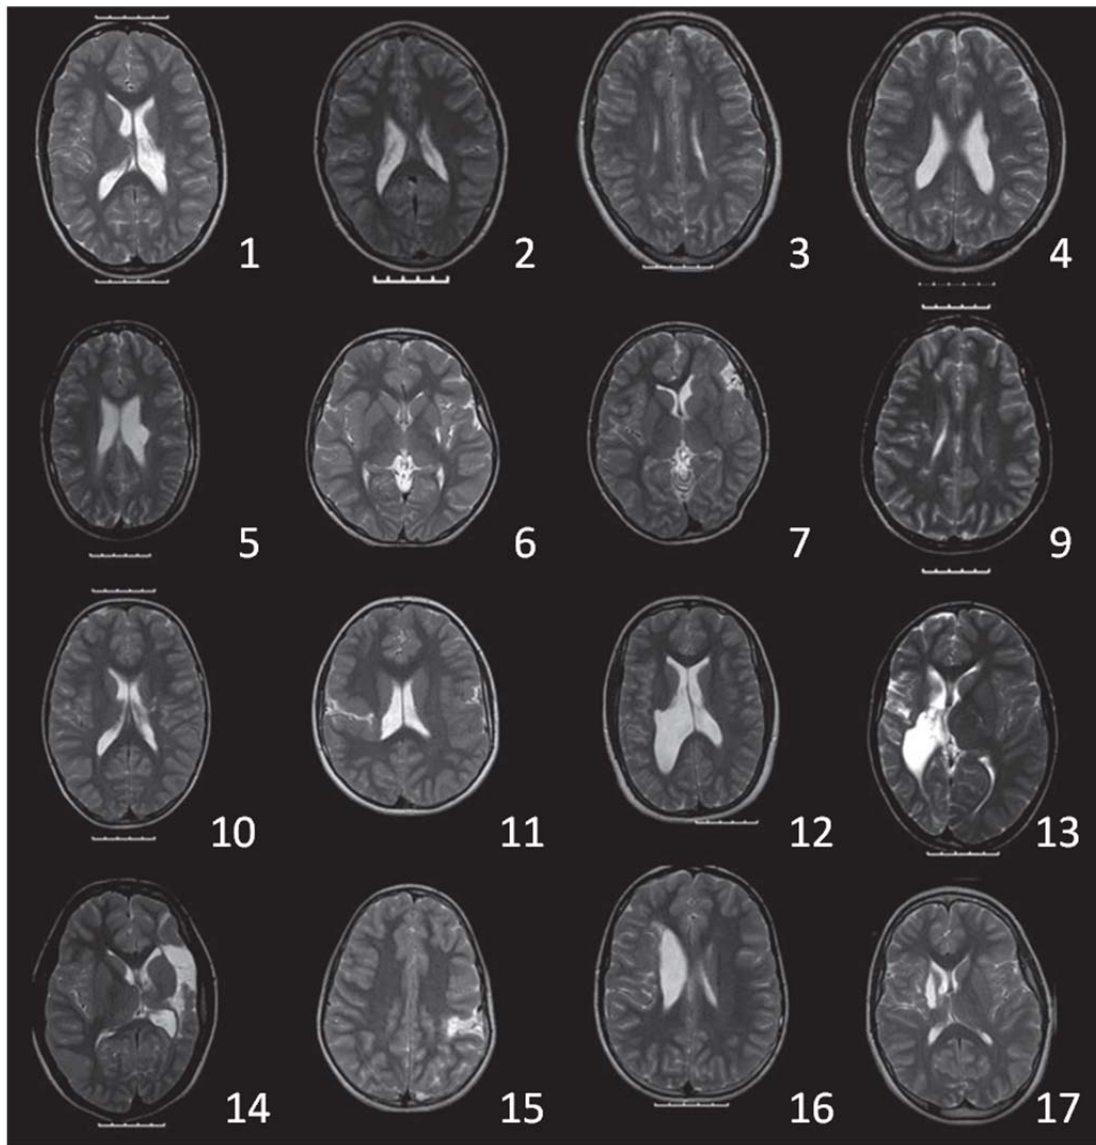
Axial slices showing each participant's lesion on T2-weighted magnetic resonance imaging. (MRI-data was not available for participant 8).
